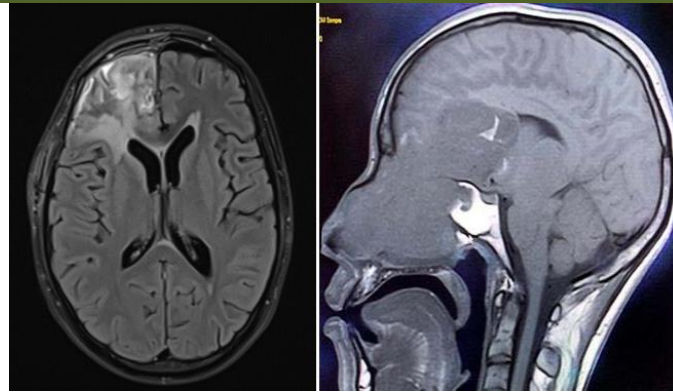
Brain MRI T2-FLAIR sequences in axial and sagittal planes showing a midfacial lesion centered on the ethmoid with intracranial extension
